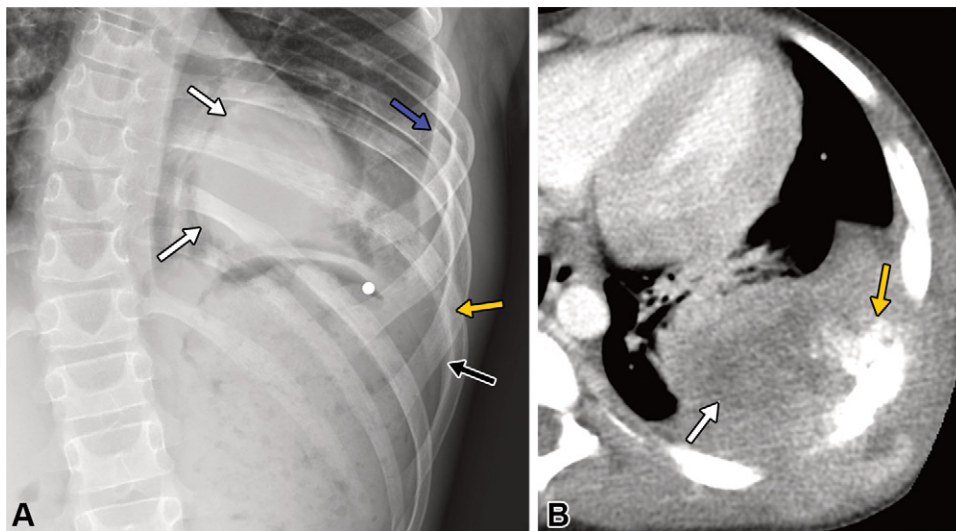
Ewing sarcoma family of tumor in a 10-year-old boy. (A) Frontal chest radiograph shows a large retrocardiac soft-tissue mass (white arrows) associated with permeative destruction (yellow arrow) and irregular periosteal reaction (black arrow) of the ninth rib as well as intercostal space widening. A small amount of pleural effusion (blue arrow) is also depicted. The spine shows a right convex curvature. (B) Axial contrast-enhanced CT image of the chest shows a large soft-tissue mass extending into the thoracic cavity and the chest wall with internal necrosis (white arrow) and eighth rib destruction with sunburstlike periosteal reaction (yellow arrow).
